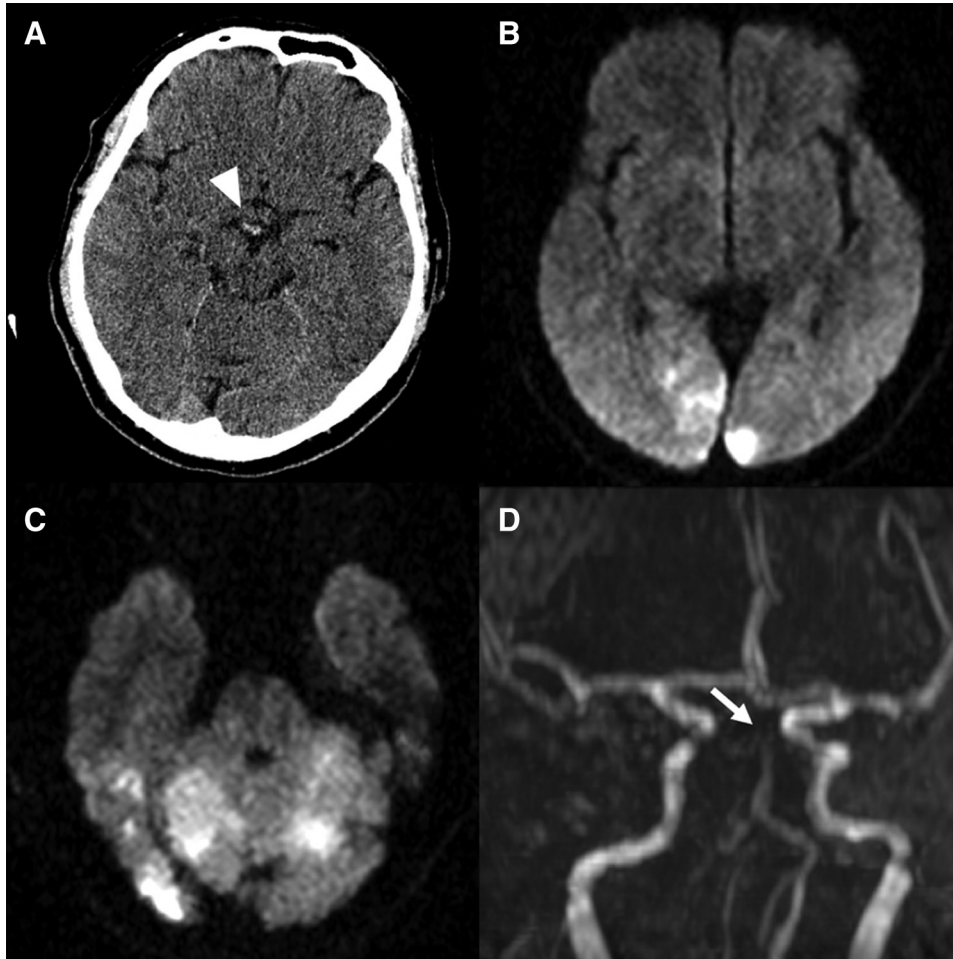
Imaging studies on the patients' arrival. (A) CT scan showing hyper-density of basilar artery tip (white arrowhead); however, the global ischemia of the posterior circulation is not evident. (B and C) On the MRI diffusion-weighted image, acute ischemic lesion was mainly located in the bilateral cerebellar hemisphere, and the bilateral thalamus and the brainstem were spared. (D) The occlusion of basilar artery tip was confirmed by time-of-flight MRA (white arrow). Comparison with the high intensity lesion in the diffusion-weighted image suggested that some ischemic penumbra remained.
